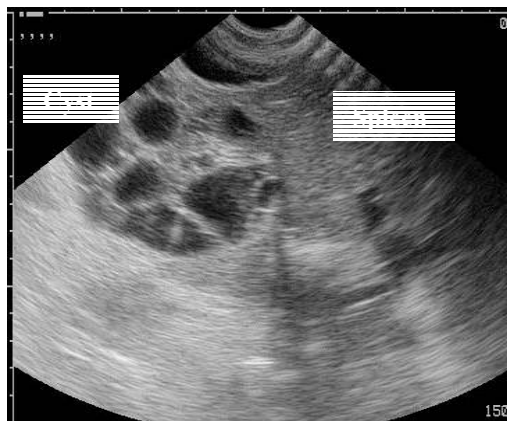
Ultrasound aspect of the cyst.
